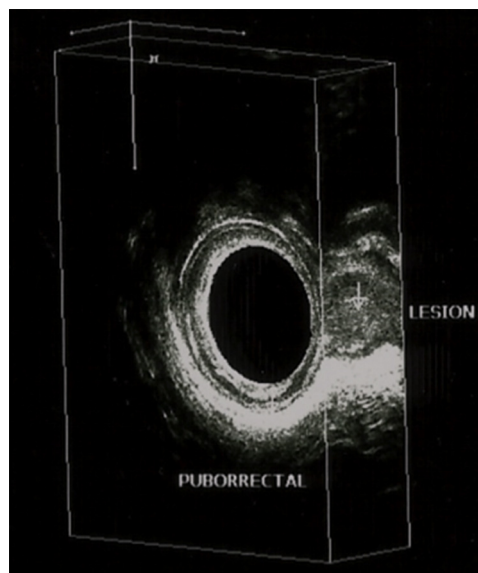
Endoanal ultrasound demonstrating the location and position of a metachronous adenocarcinoma of the anal canal.
